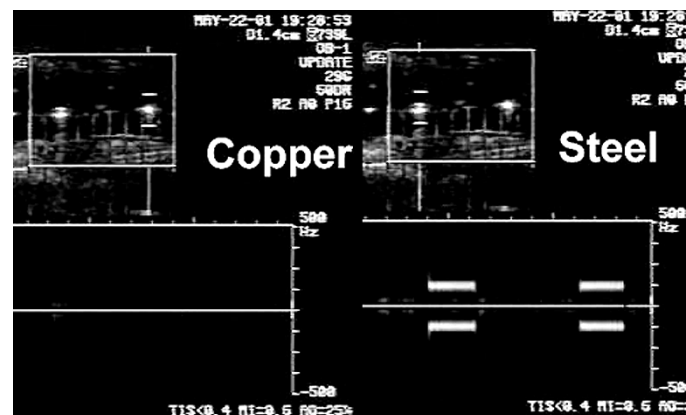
PW Doppler spectra for the seeds of Fig. 1. A Doppler signal is visible for the steel but not the copper seed.
